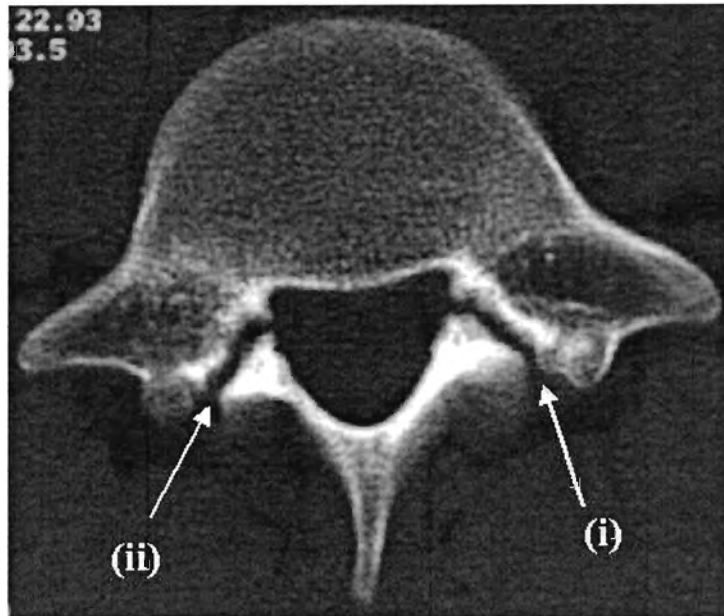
A CT scan of a 19-year-old left arm bowler taken 4 months after the first symptoms of pain in his lumbar spine. This showed an old lesion with non-bony union of the left pars interarticularis of the 5th lumbar vertebra. The right side shows a non-bony union of the pars interarticularis of the 5th lumbar vertebra.
